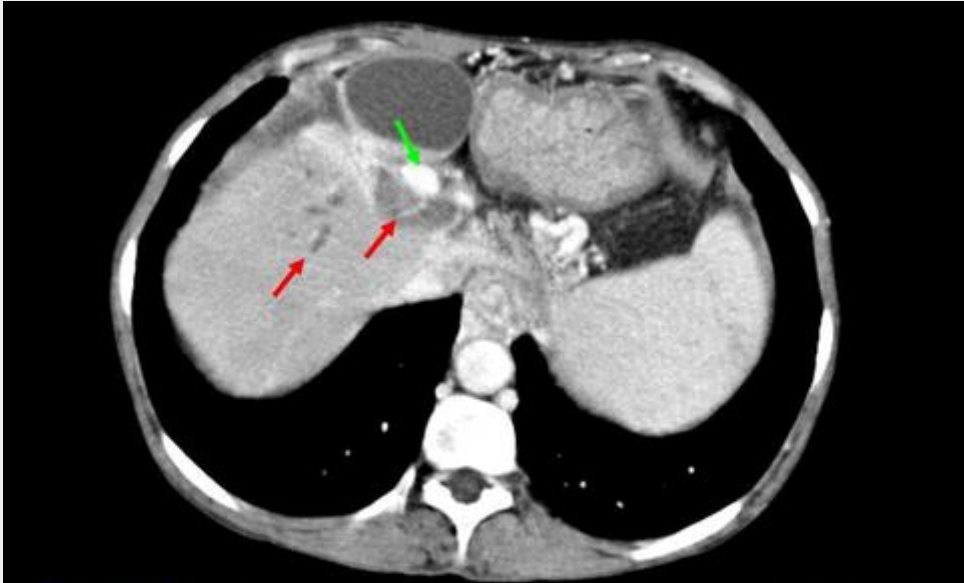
Caroli's Syndrome. Post-contrast abdominal CT better depicting the dilated bile ducts in the left lobe (→) surrounding a dilated patent umbilical vein (→) due to coexistent portal hypertension.
